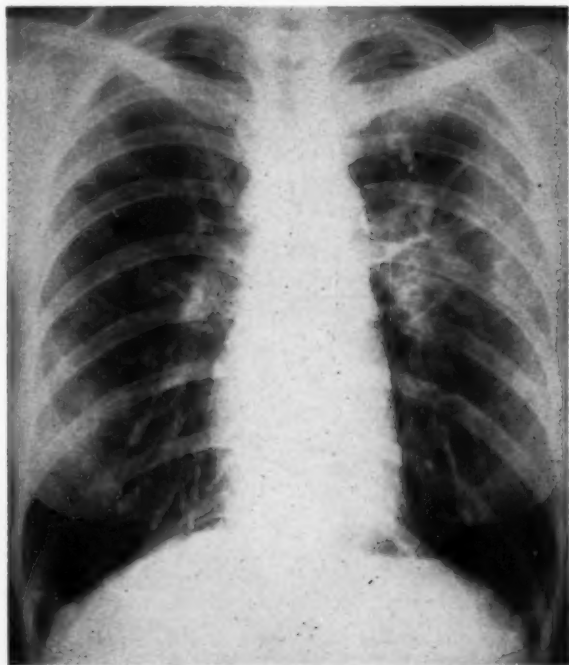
Chest roentgenogram of case of Loeffler's syndrome (proven by biopsy), showing patchy pneumonic infiltrate.
